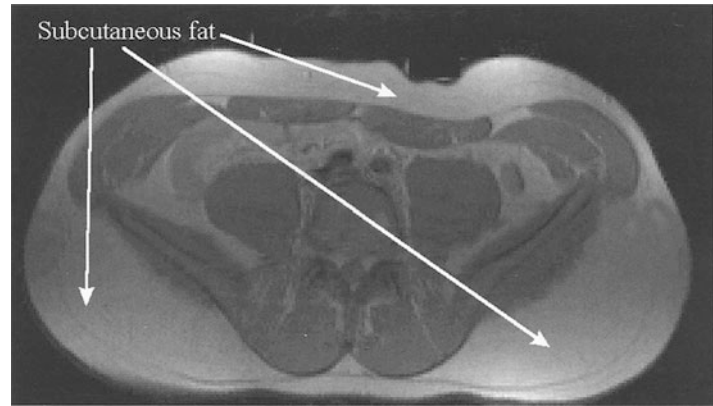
MRI cross-section of the thigh. T1 relaxation (Courtesy of Prof. Joffre, Radiology Department, Rangueil University Hospital, Toulouse, France)
